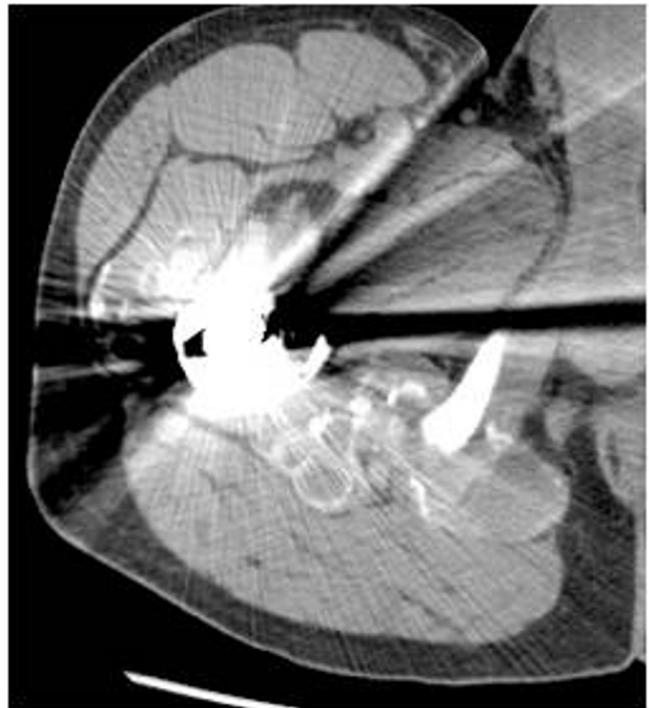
50-year-old man with extensive metallosis. Axial image from noncontrast CT of the pelvis shows more round, fluid-density lesions with metallic-density peripheral rims. The lesions are anteromedial and posterolateral to the prosthesis, along the hip joint capsule.
